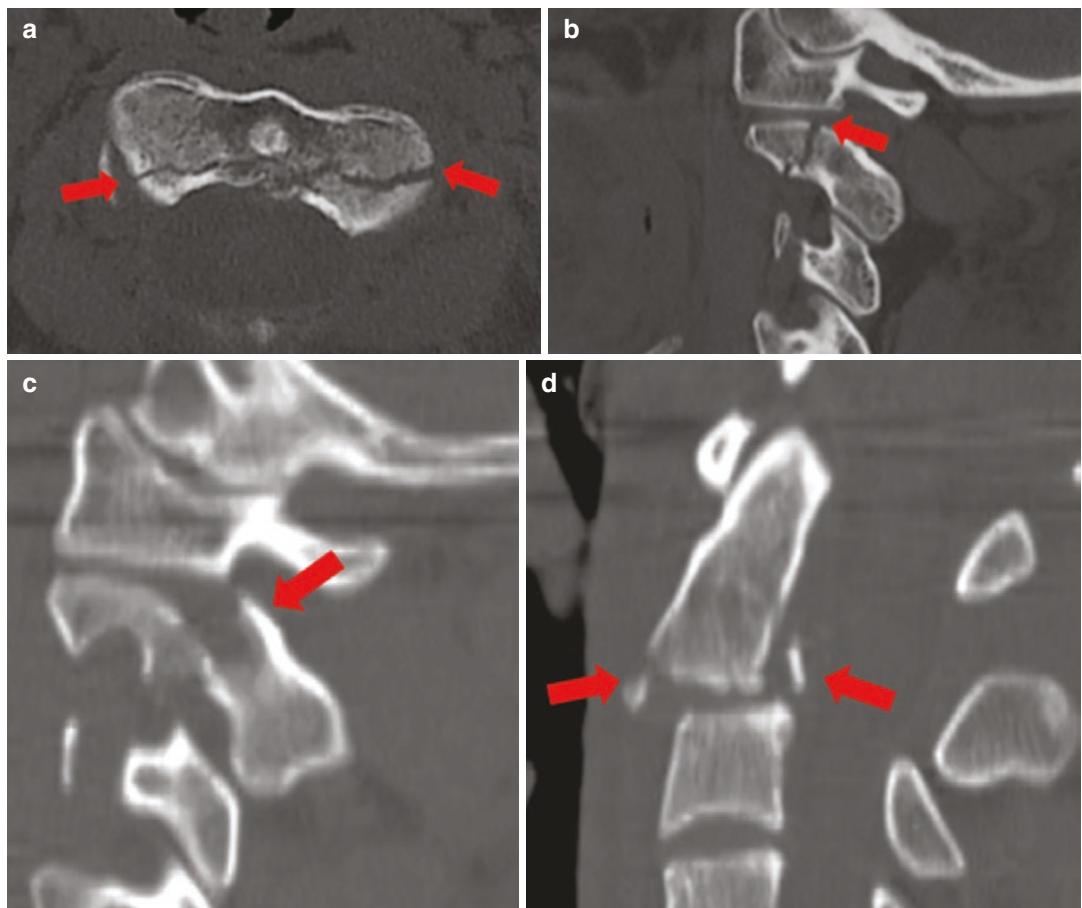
Three types of Hangman's fractures in three different patients. Type 1, CT cervical spine (a, b) axial and sagittal images show a coronal fracture involving body of C2 extending through the bilateral pars interarticularis, without anterior C2 translation; Type 2, sagittal plane (c) shows disruption of the C2–C3 disc with anterior C2 translation; and Type 3, (d) there is a combination of anterior C2 translation and angulation
